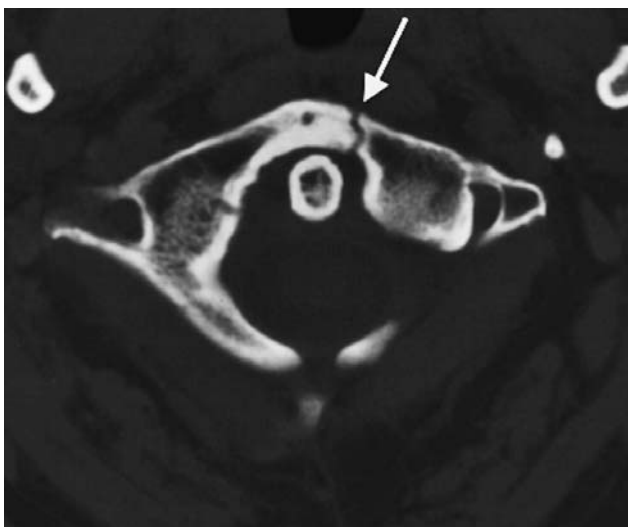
Isolated anterior arch fracture of C1. Axial CT image showing a fracture through the anterior arch of C1 (*arrow*)
